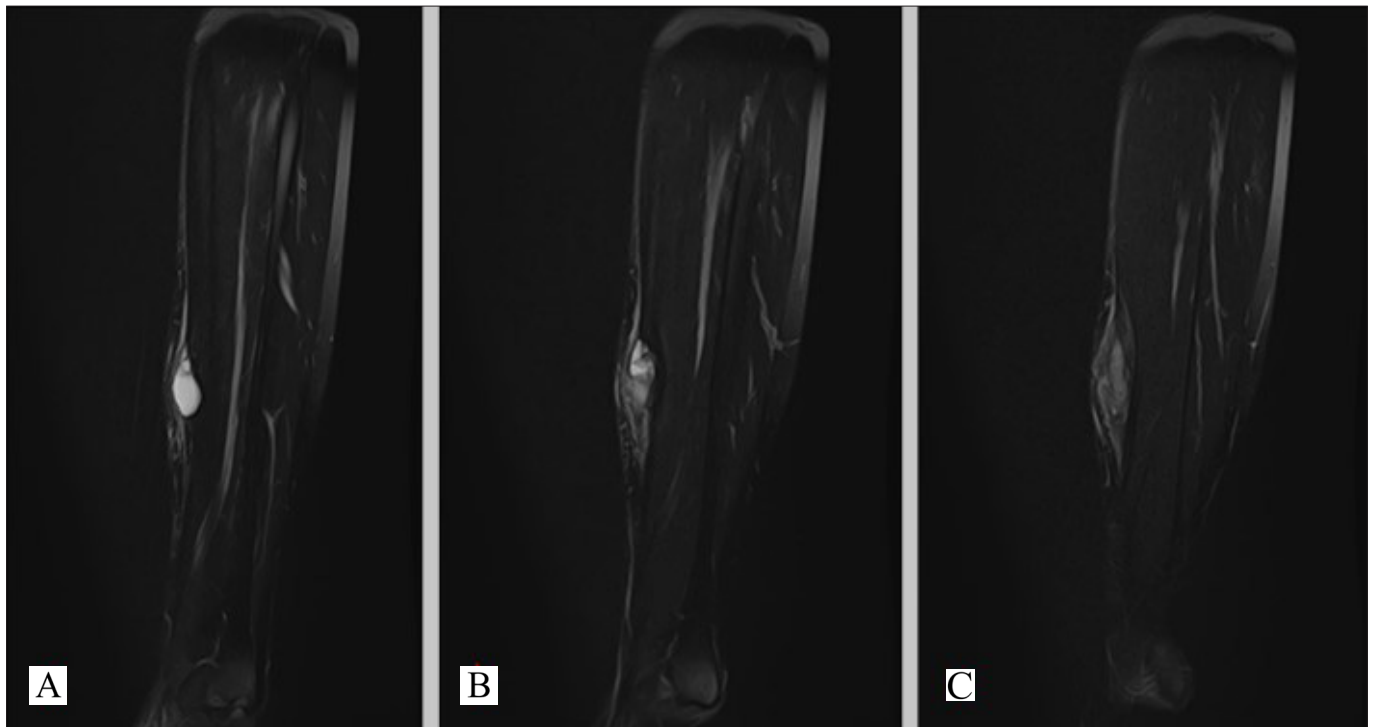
Cystic areas showing a hyperintense fluid-like signal in the sagittal T2-weighted images
